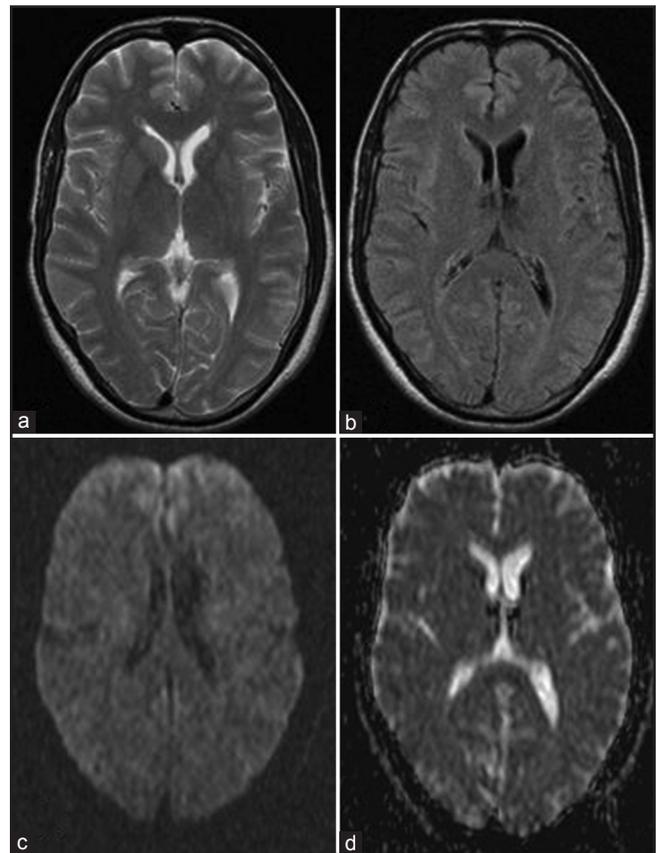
Normal appearing T2WI (a) and small area of gliosis in both thalami on FLAIR image (b), normal DWI and ADC images at 16 months follow-up (c, d)
